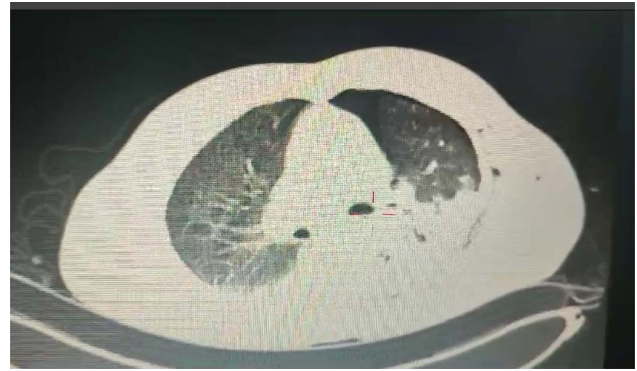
HRCT showing hemothorax.
